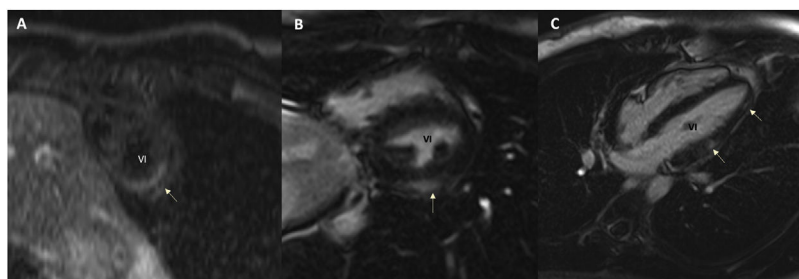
Cardiac magnetic resonance imaging study. A. Enhanced sequences (short-tau-inversion recovery [STIR]) revealed myocardial oedema in the lateral-apical aspect (arrowheads). B,C. In the later study after the intravenous administration of contrast, gadolinium uptake was observed with a subepicardial and lateral intramyocardial distribution (arrows).
